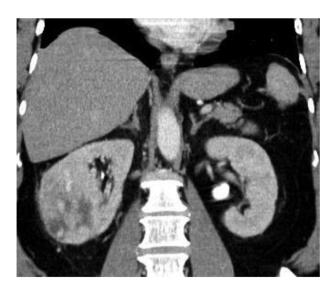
Coronal image of post contrast CT abdomen showed large right renal inferior pole mass lesion with heterogeneous enhancement.
